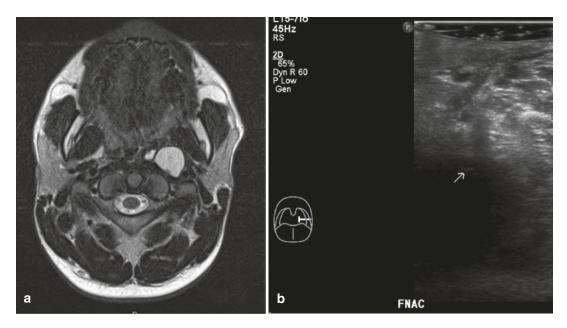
(a) A mass was found in the left parapharyngeal space on the MRI scan.US guided FNA was performed to the parapharyngeal mass as this is close to the oropharynx using a hockey stick probe to guide the needle (b)
